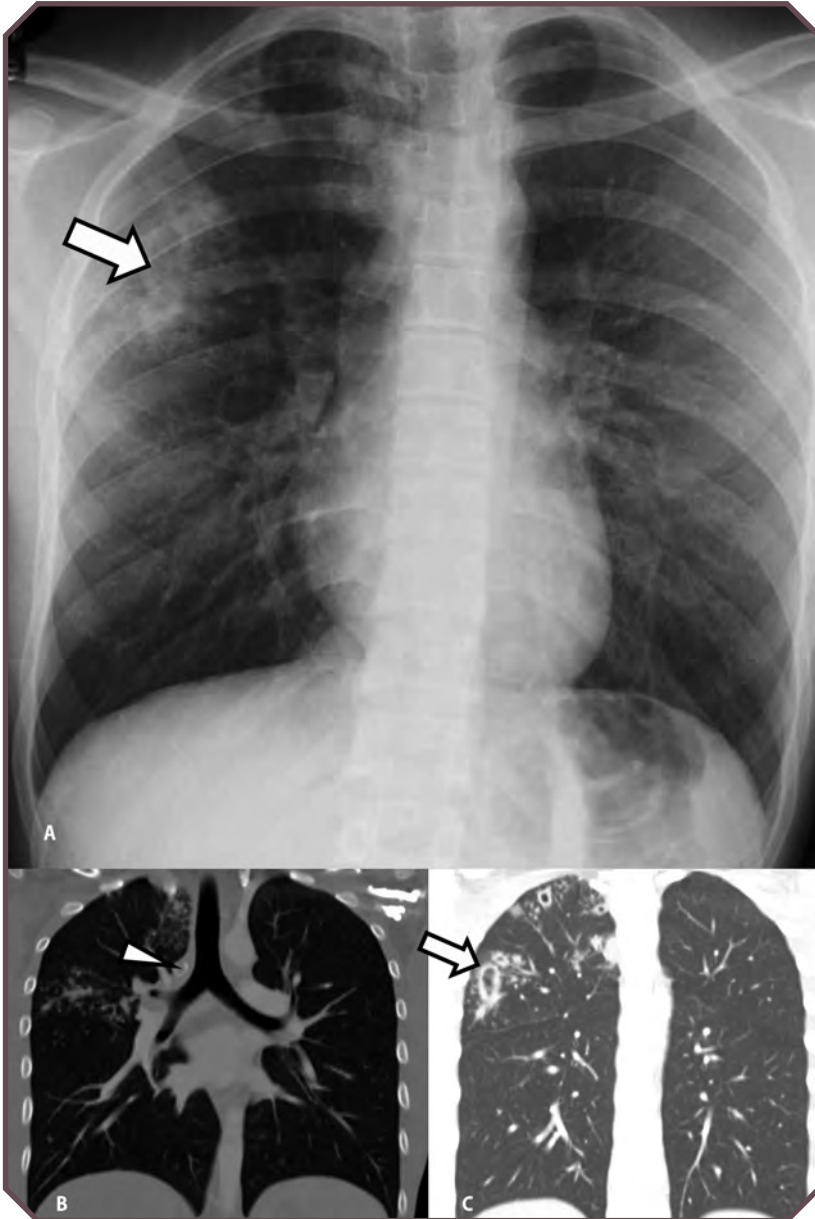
Tuberculosis in a 16-year-old girl with chronic cough. A. Frontal chest radiograph shows multiple nodules in the right upper lobe, some of which are cavitary (arrow). Coronal reconstructed images from a contrast-enhanced computed tomographic examination in B. bone and C. soft-tissue windows demonstrate nodules, some with cavitation (arrow on C), in addition to areas of tiny, miliary nodules and a calcified hilar node (arrowhead on B).
